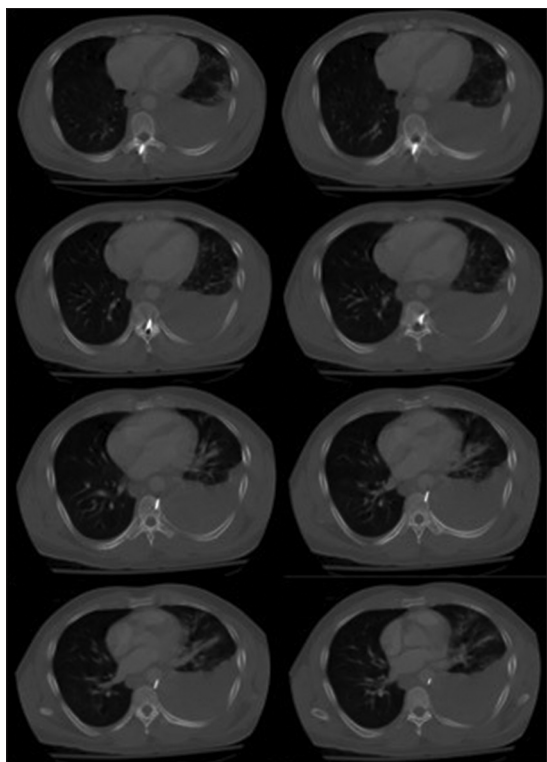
Axial computed tomography angiogram of the thorax demonstrating an 8 cm linear foreign body extending through the spinal canal and terminating in the lumen of the descending thoracic aorta. Also note a left hemothorax
